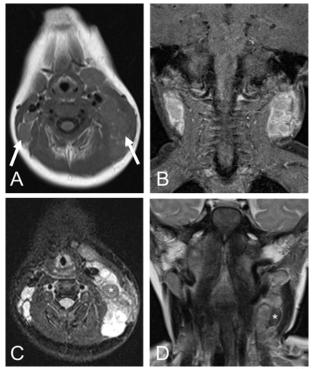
Magnetic resonance imaging of the neck. (A) Axial T1 demonstrates bilateral cervical adenomegalies (arrows) practically isointense in comparison with the muscular structures, configuring adenopathic conglomerate on the left. (B) Coronal T1 with fat saturation and after intravenous contrast reveals intense and diffuse enhancement of adenomegalies. (C) T2 Axial with fat saturation and (D) T2 Coronal show adenomegalies mostly with T2 hypersignal, and some evident hyposinal areas (asterisks).
